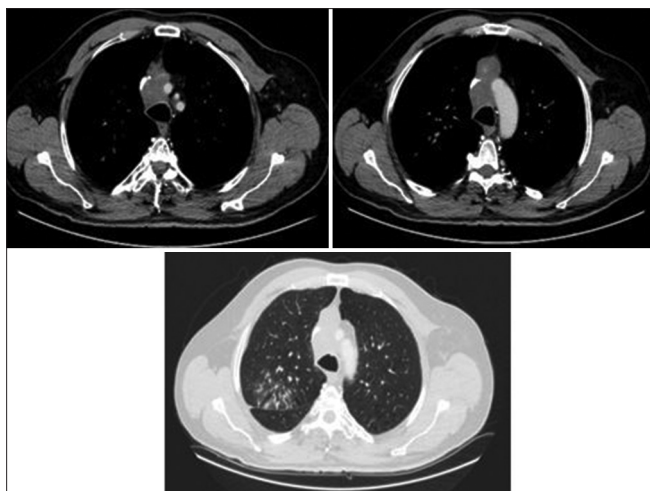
Thorax computed tomography showed significant regression of the lesion after 3 months of chemotherapy
